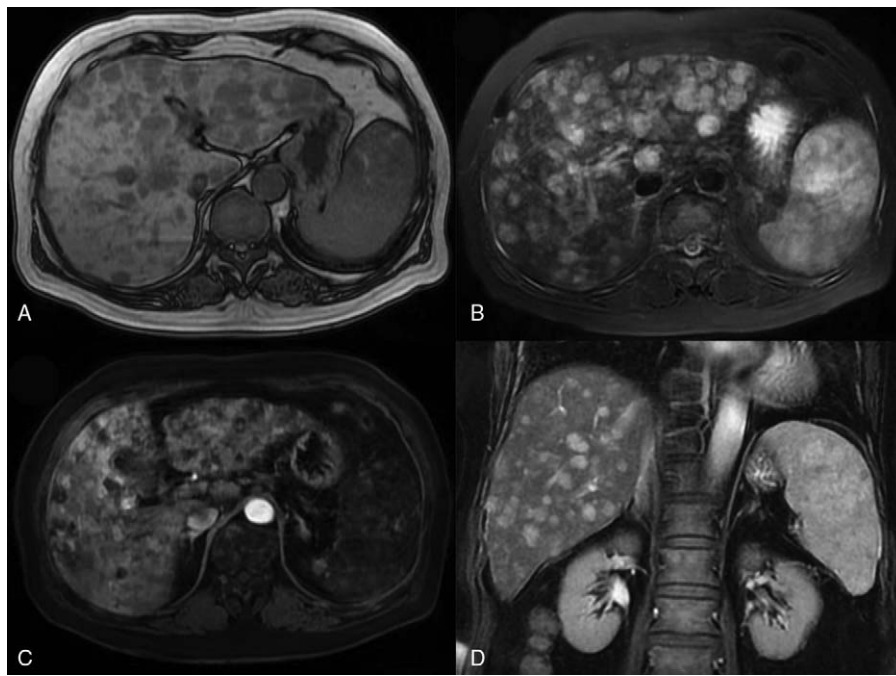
Abdomen MRI performed diffuse distribution of circular nodules in liver and spleen of diverse size, margin clear lesions with low signal in T1WI (A), high signal in T2WI (B), the spleen enlarged. No swelling lymph node. The signal was uneven and enhanced in axial view (C) and coronal view (D).
